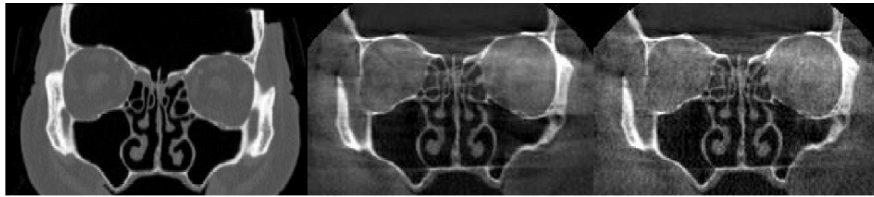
Comparing of conventional CT to of an intact post mortem head to 3D-RX on a mobile surgery X-ray system (upper row). From left to right a CT, 3D-RX high quality (375 projections) and a 3D-RX normal quality (151 projections). Data courtesy of Prof. Dr. med. et Dr. med. dent. Beat Hammer, Cranio-Faciales-Centrum, Hirslanden Clinic, Aarau, Switzerland.
